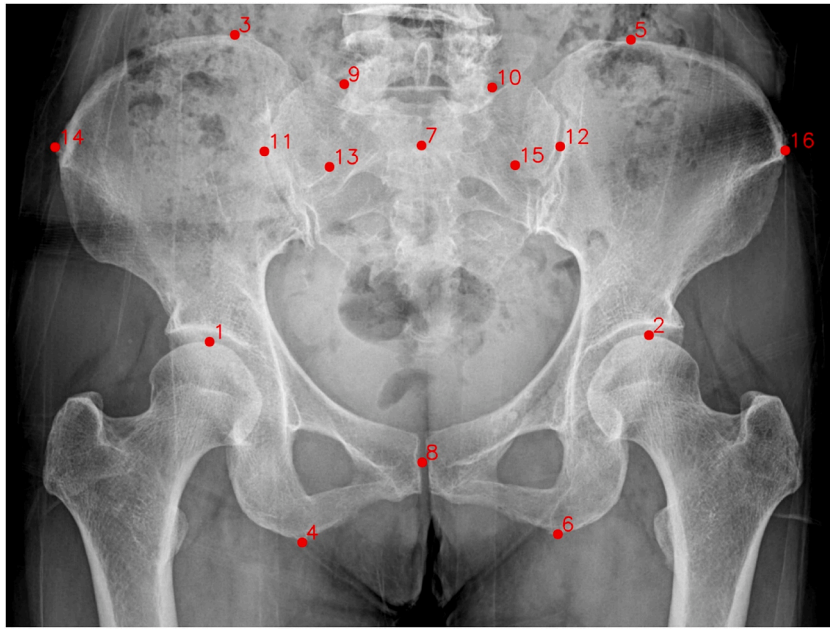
Landmarks used to measure radiographic parameters for assessing pelvic displacement.
